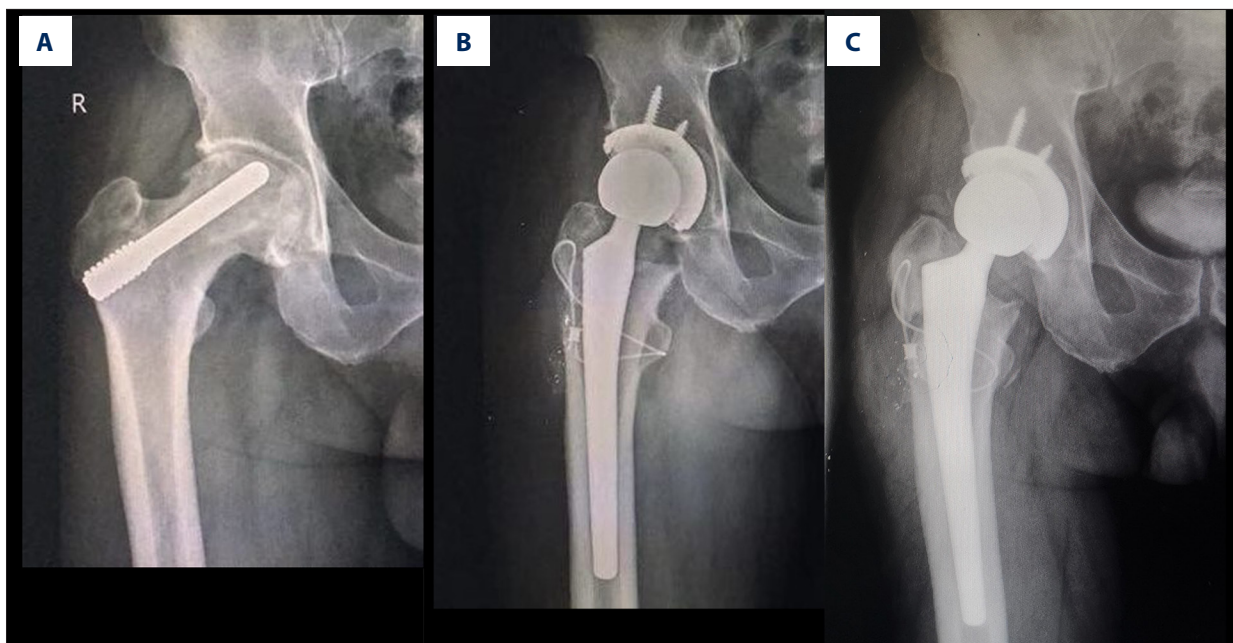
A 50-year-old male patient sustained a trochanteric fracture during conversion to total hip arthroplasty (THA) using the retrograde procedure. (A) Pre-operative x-ray image; (B) Post-operative x-ray image (at 1 month after THA) shows the trochanteric fracture and tantalum debris; (C) Nonunion of the trochanteric fracture 2 years later.
